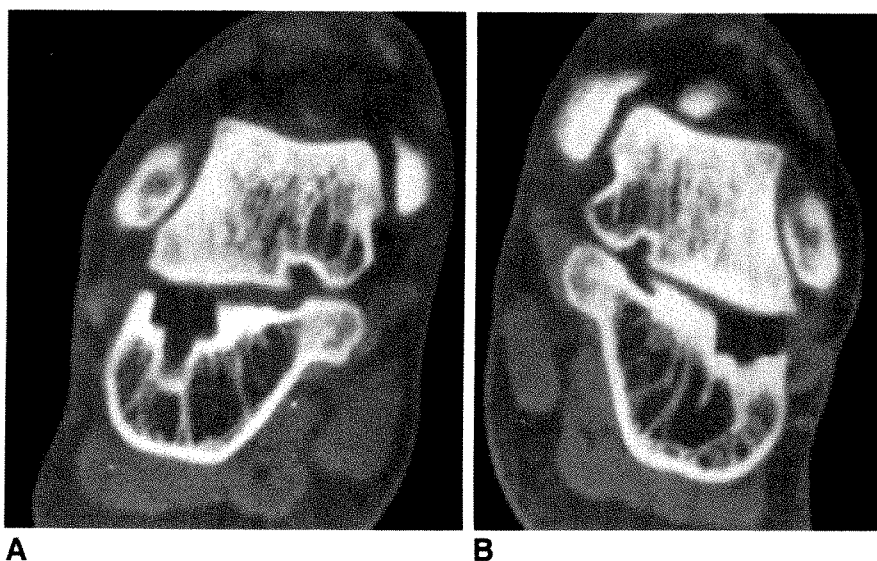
A and B, Coronal CT scans of bilateral STA-Peg implants in 11-year-old girl with excessive recession and posterior positioning within calcaneus (left greater than right) associated with suboptimal correction of flatfoot deformities. Abnormal positioning may have resulted from excessive resection of dorsal calcaneus. Surgical revision was not recommended because of technical difficulty of revision and mild symptoms.
